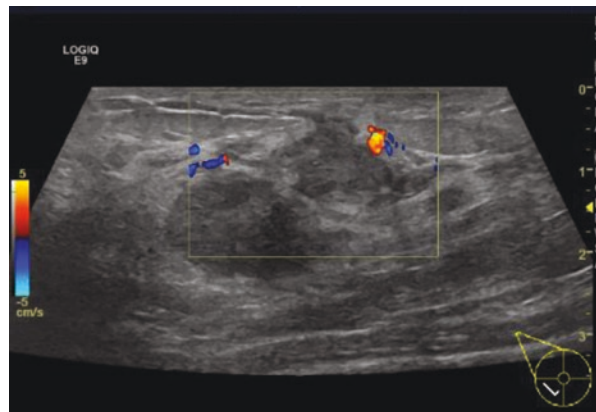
Interdigitating extension of hypoechoic change between the fatty lobules on ultrasound. Hyperechoic change of the intramammary fatty lobules is also present. This appearance is nonspecific and represents diffuse inflammatory change. This can be present in IGM (4a) as well as lactational (4b) and non-lactational mastitis
